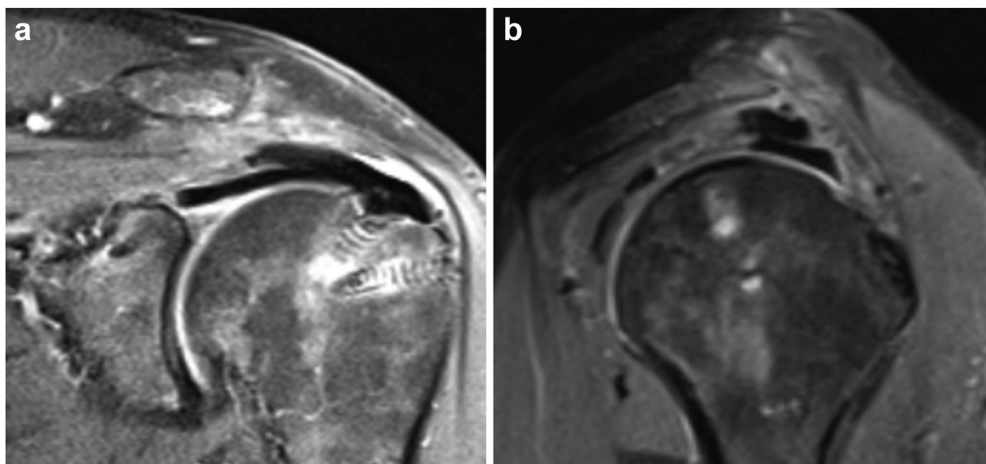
(a) Postoperative coronal and (b) sagittal T2 MRI at three months showing the dual grafts used for reconstruction of the superior capsule and rotator cuff. MRI, magnetic resonance imaging.
